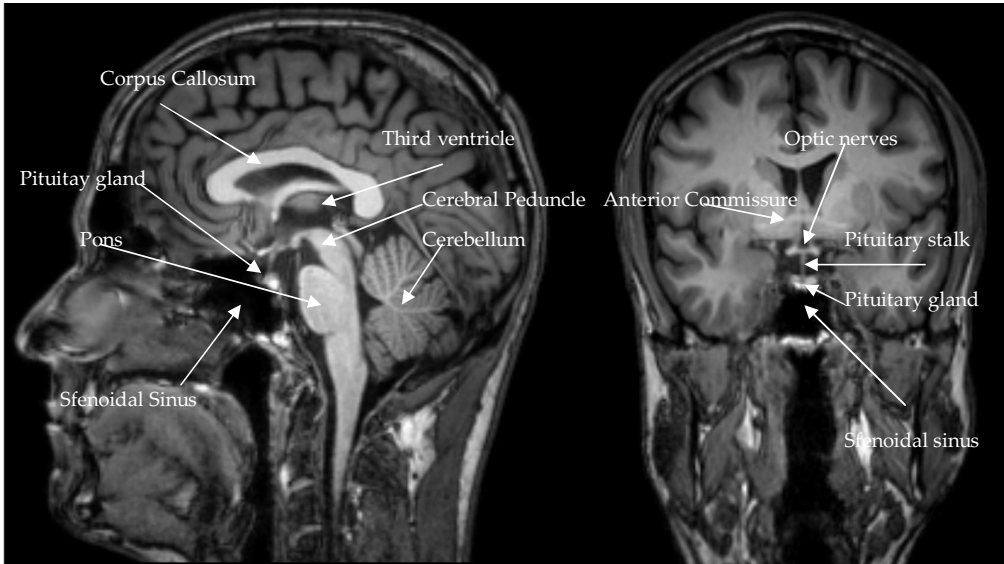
This T1 weighted 3T MR image shows the anatomy of the brain of a normal control individual in the mid sagittal and coronal plane.
